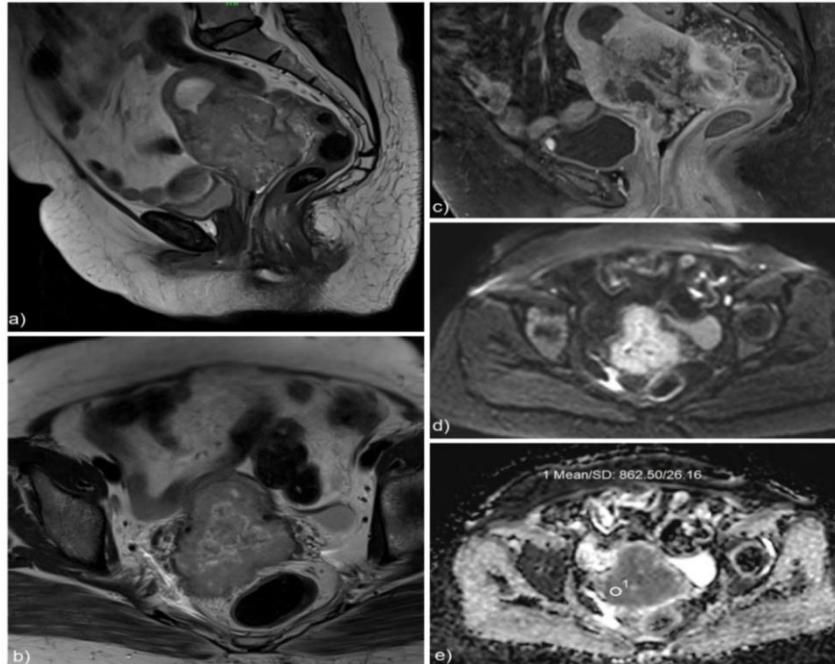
MRI pelvis showing moderately differentiated squamous cell carcinoma cervix; a) Sagittal T2W image showing bulky cervix with a large hyperintense lesion with irregular and poorly defined margins; b) Axial T2W image showing extent of the lesion invading bilateral parametria and mesorectal fat planes; c) Sagittal post contrast T1FS image showing heterogeneous enhancement of the lesion with few non-enhancing necrotic areas; d) & e) are b value and ADC images of diffusion weighted imaging, showing peripheral diffusion restriction, with corresponding low ADC value of $0.86 \times 10^{-3} \text{mm}^2/\text{s}$.
